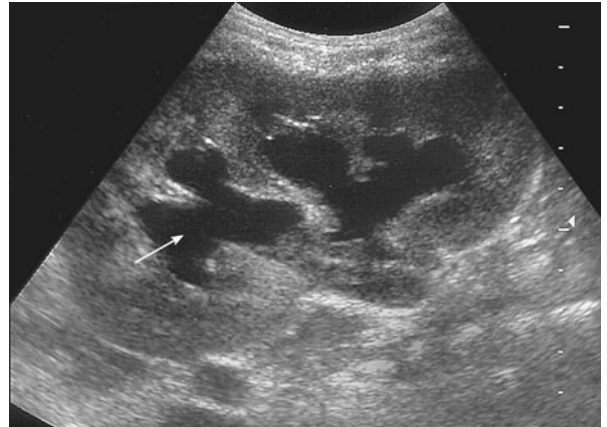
Renal ultrasound of obstruction. Shown by the arrow is the dilated renal pelvis surrounded by the kidney. This finding is referred to as *hydronephrosis*.
